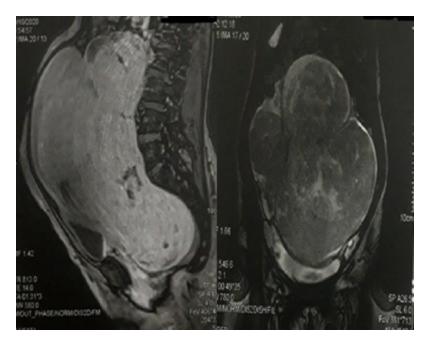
MRI showing a large uterine abdominal pelvic mass measuring 25x7x22 cm., highly vascularized, suggesting the appearance of uterine sarcoma.
